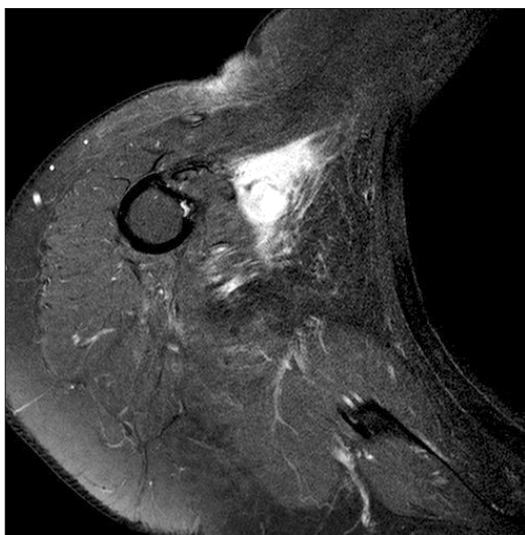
A magnetic resonance imaging revealed a new generated tumor at her right axilla.
